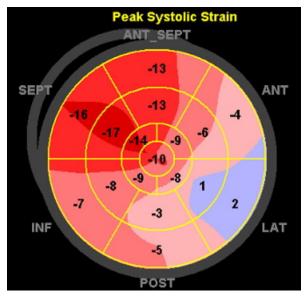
Polar map from speckle-tracking echocardiography shows bull's-eye representation of left ventricular global longitudinal systolic strain. Severely reduced strain is evident in the anterior, lateral, and inferior walls.
